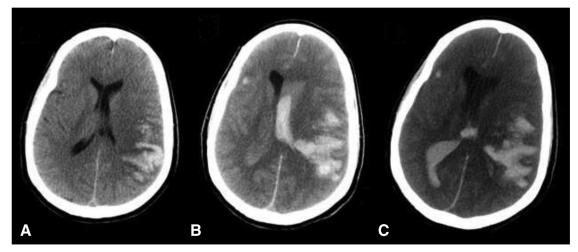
Computed tomography scans of the head at 4.5 h (A), 6.5 h (B), and 20 h (C) after symptom onset.
